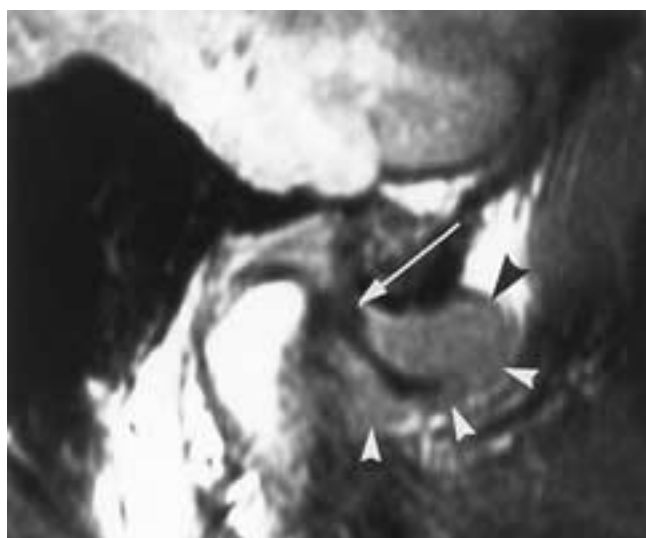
Synovial chondromatosis. Sagittal MR image showing expansion of the upper and lower joint spaces (arrowheads). The disk (arrow) is anteriorly displaced.
